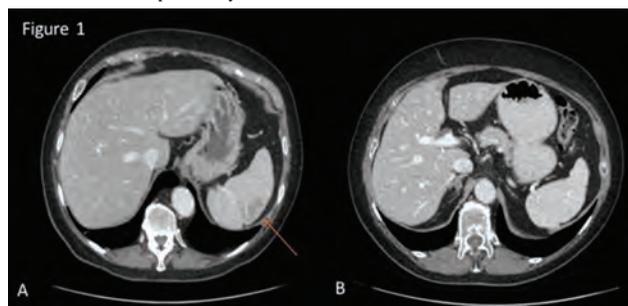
CT image (A) showing splenic infarction with radiologic improvement (B) after CMV treatment.
